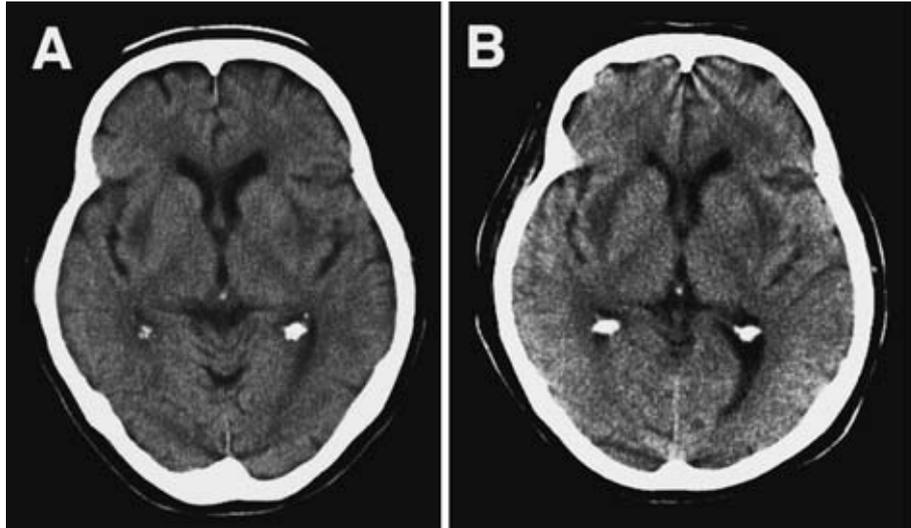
CT scans obtained on admission and on the following day. Low-density areas were seen bilaterally in the caudate head, insula cortex, and the external portion of the putamen on admission (A). The low-density areas were mildly extended on the following day (B).
